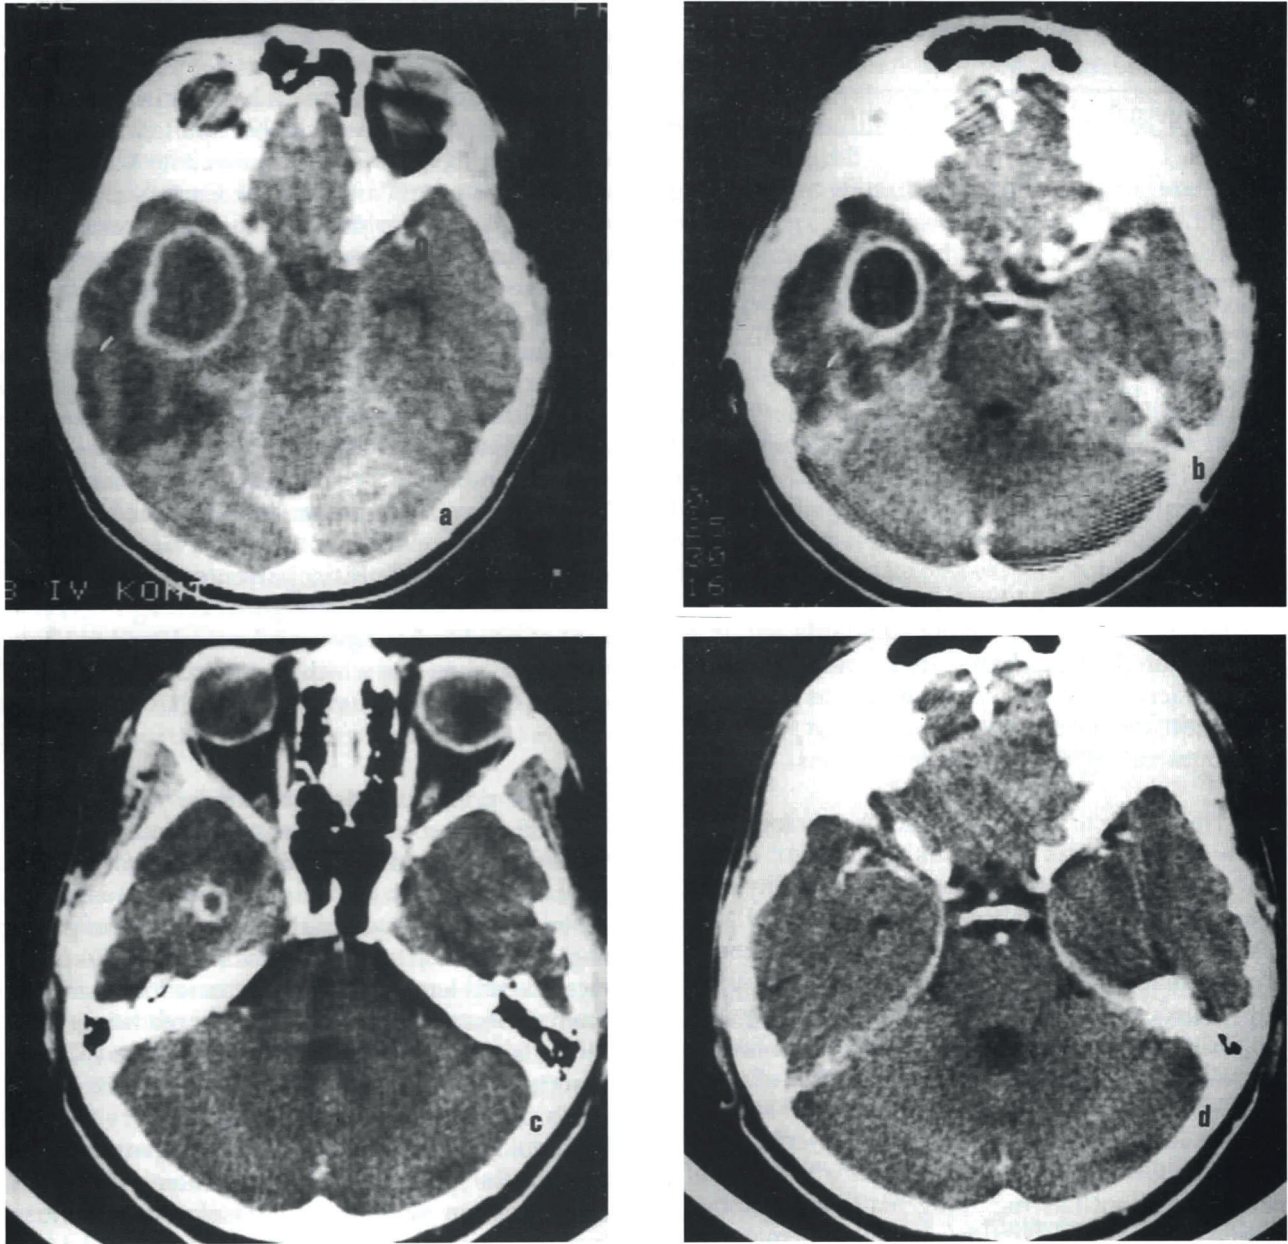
Serial CT scans of a case of temporal abscess, a) temporal abscess with peripheral edema before treatment, b) after the first aspiration the size of the abscess was decreased, c) after the second aspiration the abscess cavity was decreased markedly, but there is still small abscess with rim enhanced capsule, d) the treatment continued with antibiotics, and there is no abscess in CT scan with contrast performed 1 year after the treatment.
